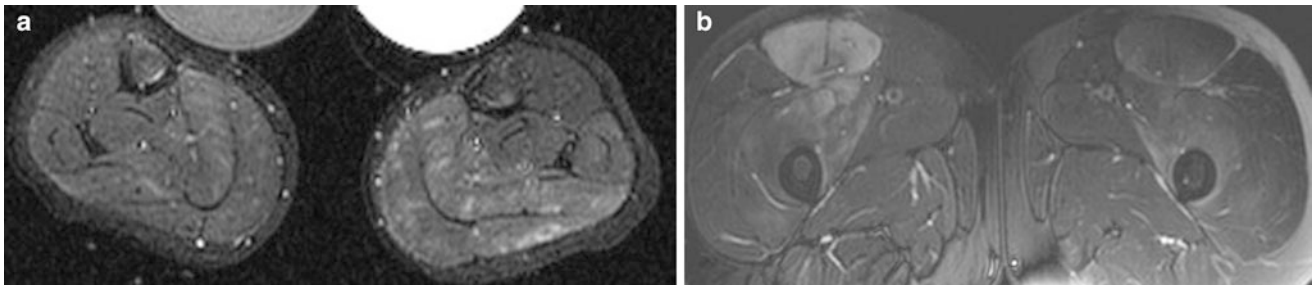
a Axial STIR images of both lower legs in a 7-year-old boy with Duchenne muscle dystrophy and edema like changes most pronounced in the left triceps surae muscle. b Axial fat-saturated T2-weighted MR image of both thighs in a 25-year-old rugby player
